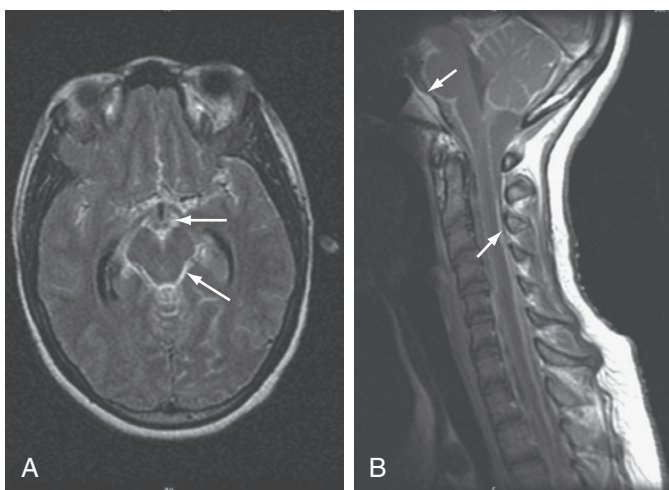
■ Tuberculous meningitis. T1-weighted (A) transverse MRI of the brain and (B) sagittal MRI of the base of the brain and the spinal cord in a patient with tuberculous meningitis. Note the enhanced meninges (arrows) in the basilar regions of the brain, brainstem, and spinal cord.
